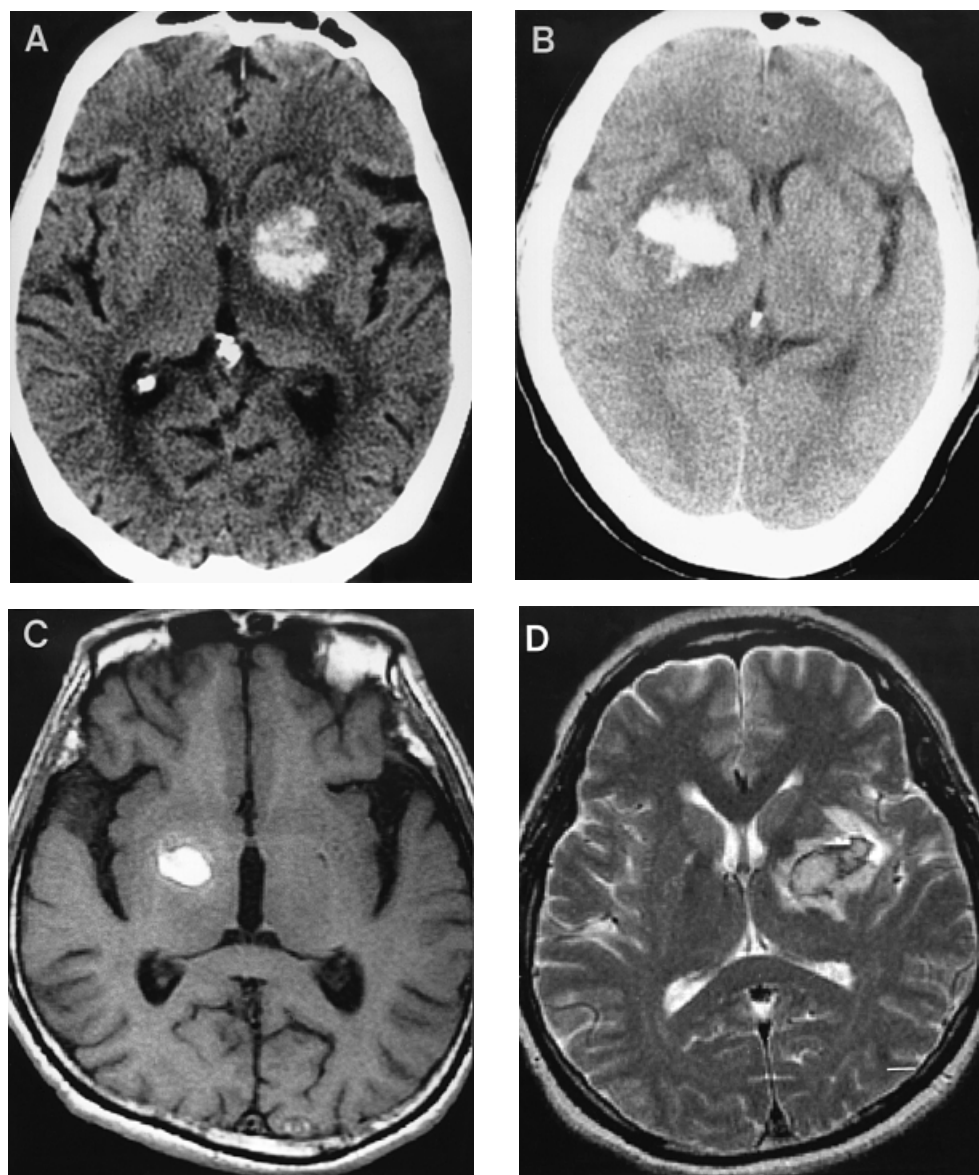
CT (A and B), T₁-weighted (C) and T₂-weighted MR (D) images showing the middle type of SCH. Haematomas develop in the middle and medial portion of the lentiform nucleus (mostly globus pallidus and medial portion of the putamen), often extending in the lateral direction. They do not rupture into the ventricles. Each picture is from a different patient.
